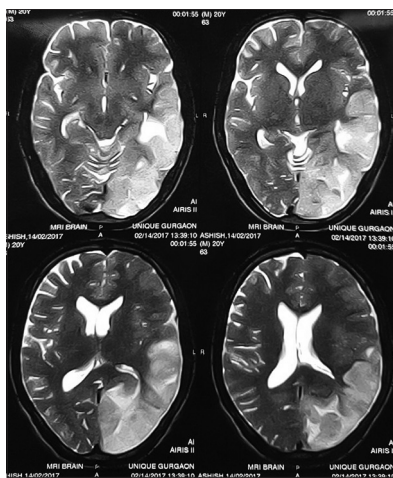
Magnetic resonance imaging of the brain showing infarct in the left temporoparietal and occipital lobes with significant perilesional edema
